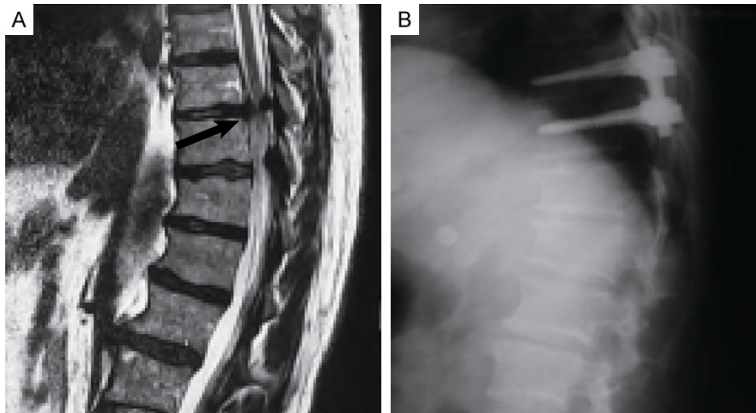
Typical preoperative and postoperative images of patients with thoracic spinal stenosis. A. Preoperative MRI scans, with the arrow showing the thoracic spinal stenosis lesion; B. Postoperative lateral radiograph.
